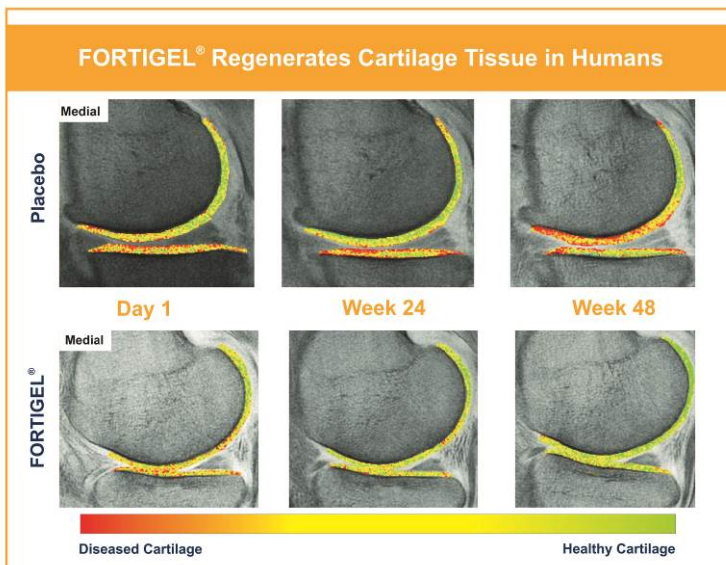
The amount of proteoglycans was statistically and significantly increased in FORTIGEL®-treated osteoarthritic patients when compared with a placebo. The positive effect of Bioactive Collagen Peptides® was clearly visualized using the magnetic resonance imaging technique, dGEMRIC.
